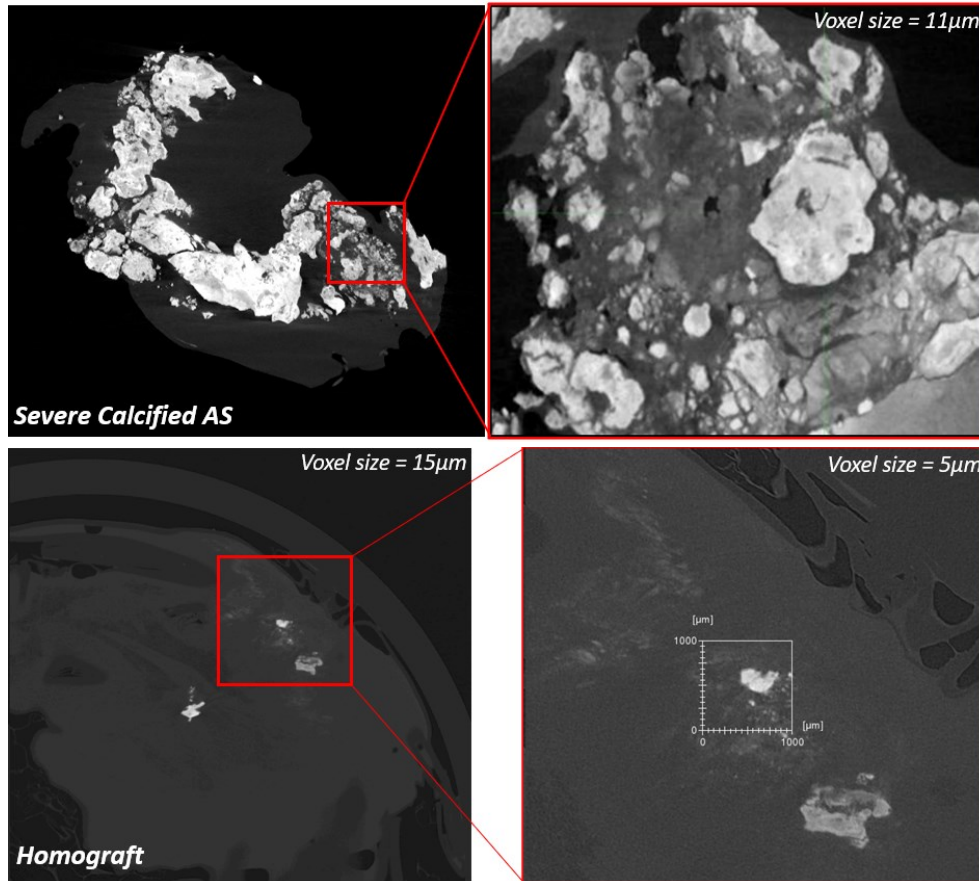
High-resolution CT images displaying the microstructure of calcific clusters within a severely calcified valve (top images) and a homograft (bottom images). In the bottom right image, a region of micro-attenuation resembling fine sand can be observed, corresponding to areas of microcalcifications. Interestingly, we also identified several calcified regions in the control valves with varying densities, demonstrating the presence of an “ongoing” calcification process.
